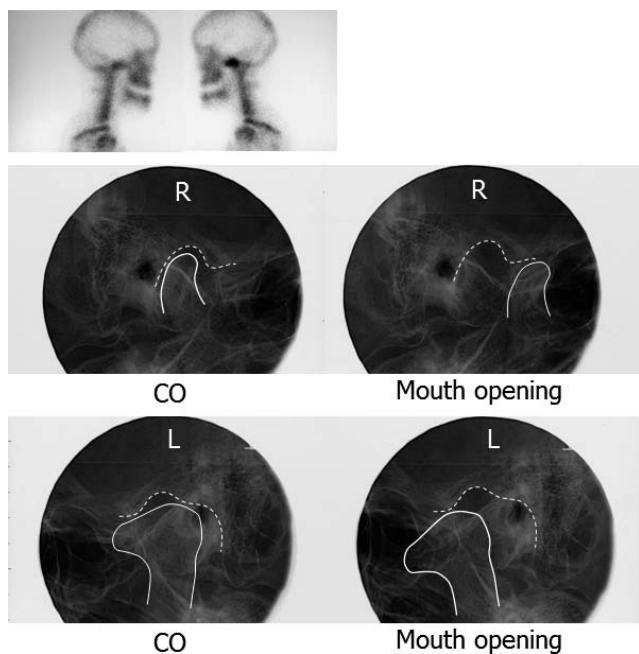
Pretreatment bone scintigraphy and temporomandibular joint radiographs obtained by the Schuller method.
